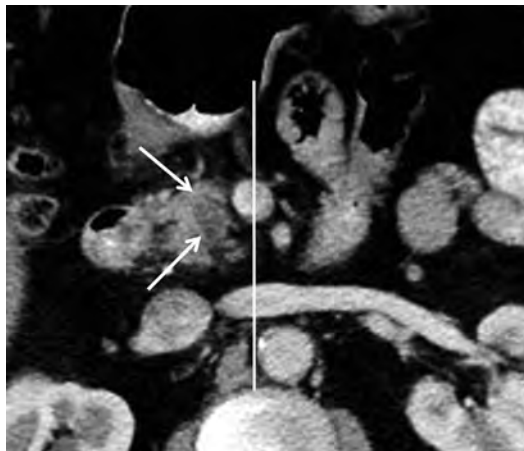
In a 59-year-old man with abdominal pain, CT scan in the late arterial phase shows a hypodense pancreatic head/uncinate mass (arrows) to the right of the superior mesenteric vein (SMV) (vertical line) with no involvement of the SMV or superior mesenteric artery. This case was resectable.
